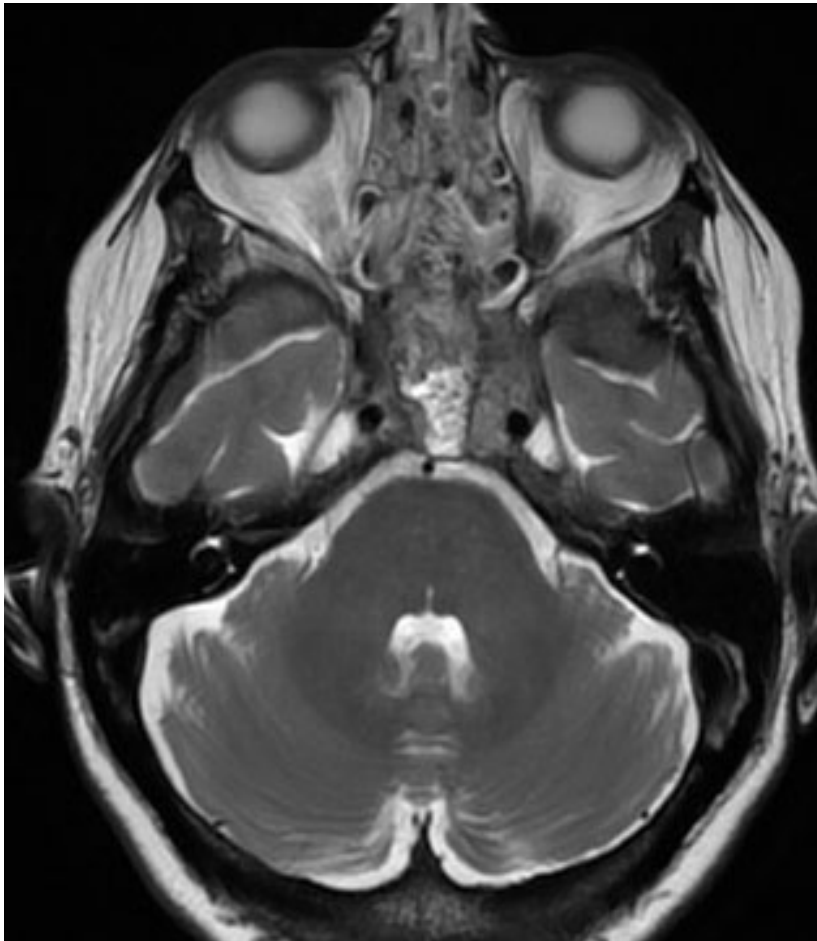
Transaxial T2 weighted MRI showing the high signal central defect in the central and posterior aspect of the tumour.
